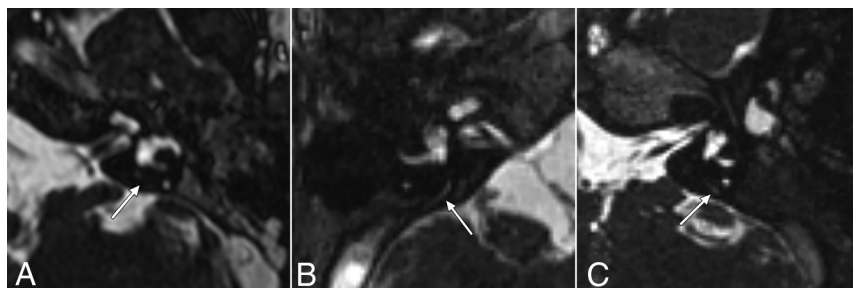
CISS MR images demonstrating additional examples of type 2 (faintly visible) ELDs (arrows) in 3 different patients: A, A 4-year-old girl with mild SNHL in the left ear. This patient demonstrated EVA on CT. B, A 1-year-old boy with profound SNHL in the right ear. This patient did not have VA enlargement on CT. C, An 8-year-old girl with profound SNHL in the left ear. This patient did not have VA enlargement on CT.
